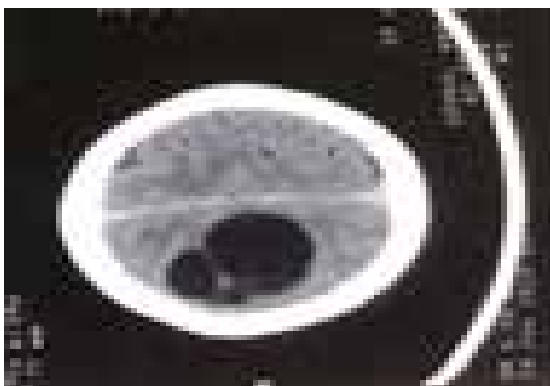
CT brain showing hypodense hydatid cyst
